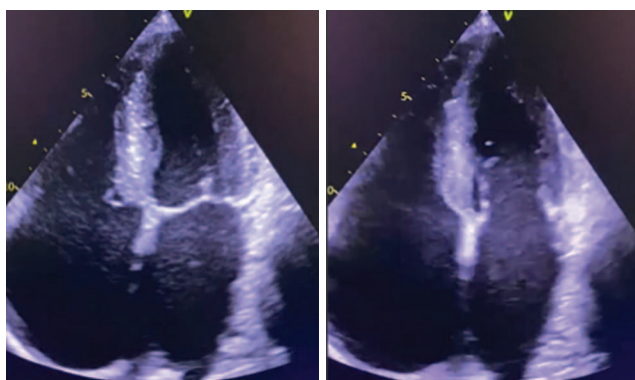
Echocardiography from 19.01: mild hypokinesia of the anterior septal and anterior walls of the left ventricle
